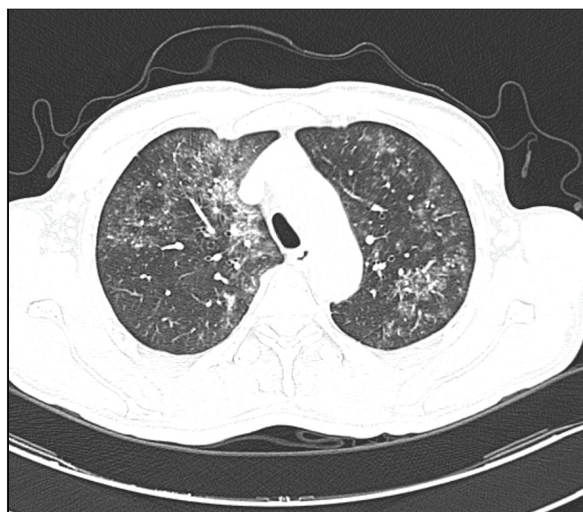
High-resolution CT scans of the chest.
